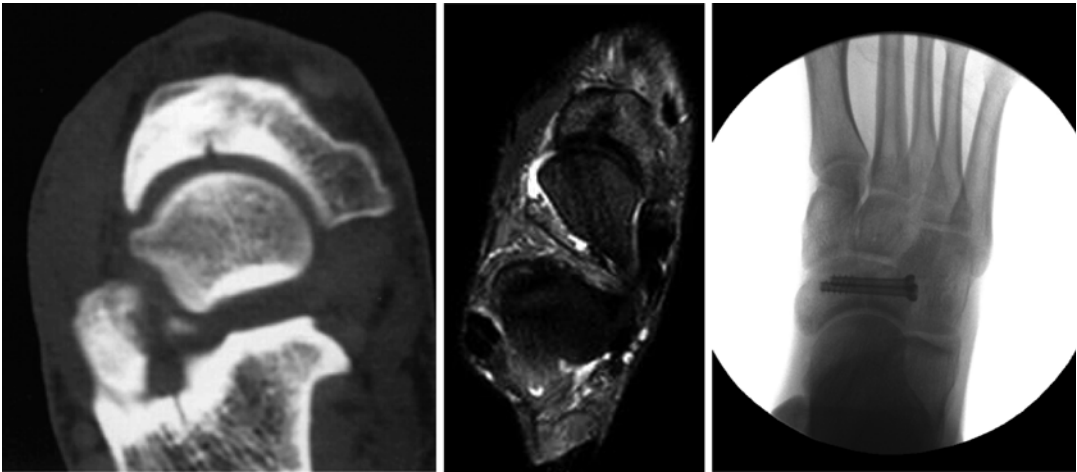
Navicular stress fracture as shown by CT and MRI. Surgical treatment with 2 cannulate screw and bone grafting
